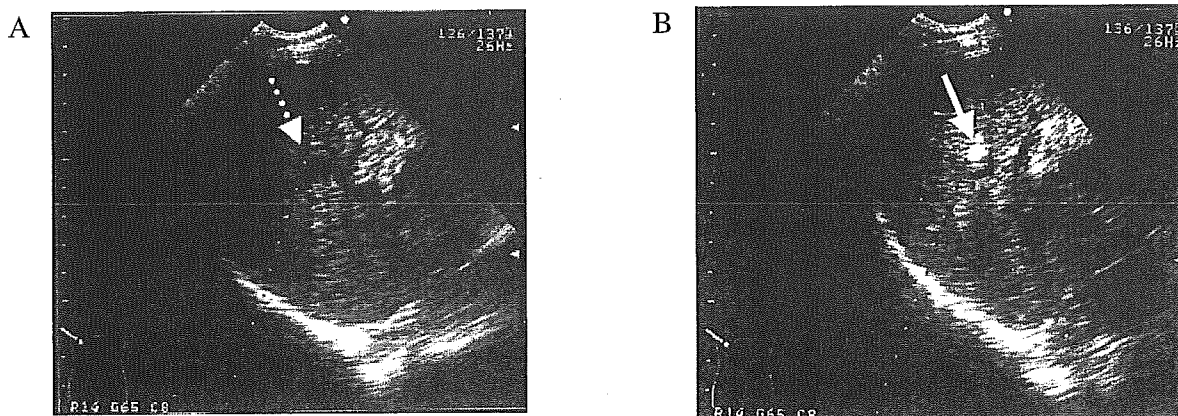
Hypochoic tumor with a diameter of 12 mm, is visualized at segment 5 of the liver using ultrasonography in patient 2 (A, dotted arrow). After an injection of ethanol into the tumor, injected area changes to hyperechoic (B, solid arrow).
